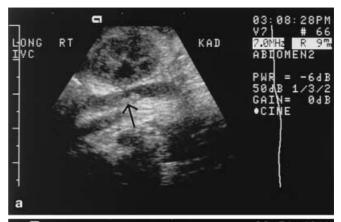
Ultrasound images of mural and sheath catheter-related thrombosis. (a) Longitudinal image of the inferior vena cava just cranial to the iliac veins revealing a lumen occluded with an echogenic, irregularly contoured mural thrombus (arrow) (b) Longitudinal image of the right iliac vein demonstrating a sheath thrombus that mimics the shape of the catheter recently removed from the right groin (arrow)
